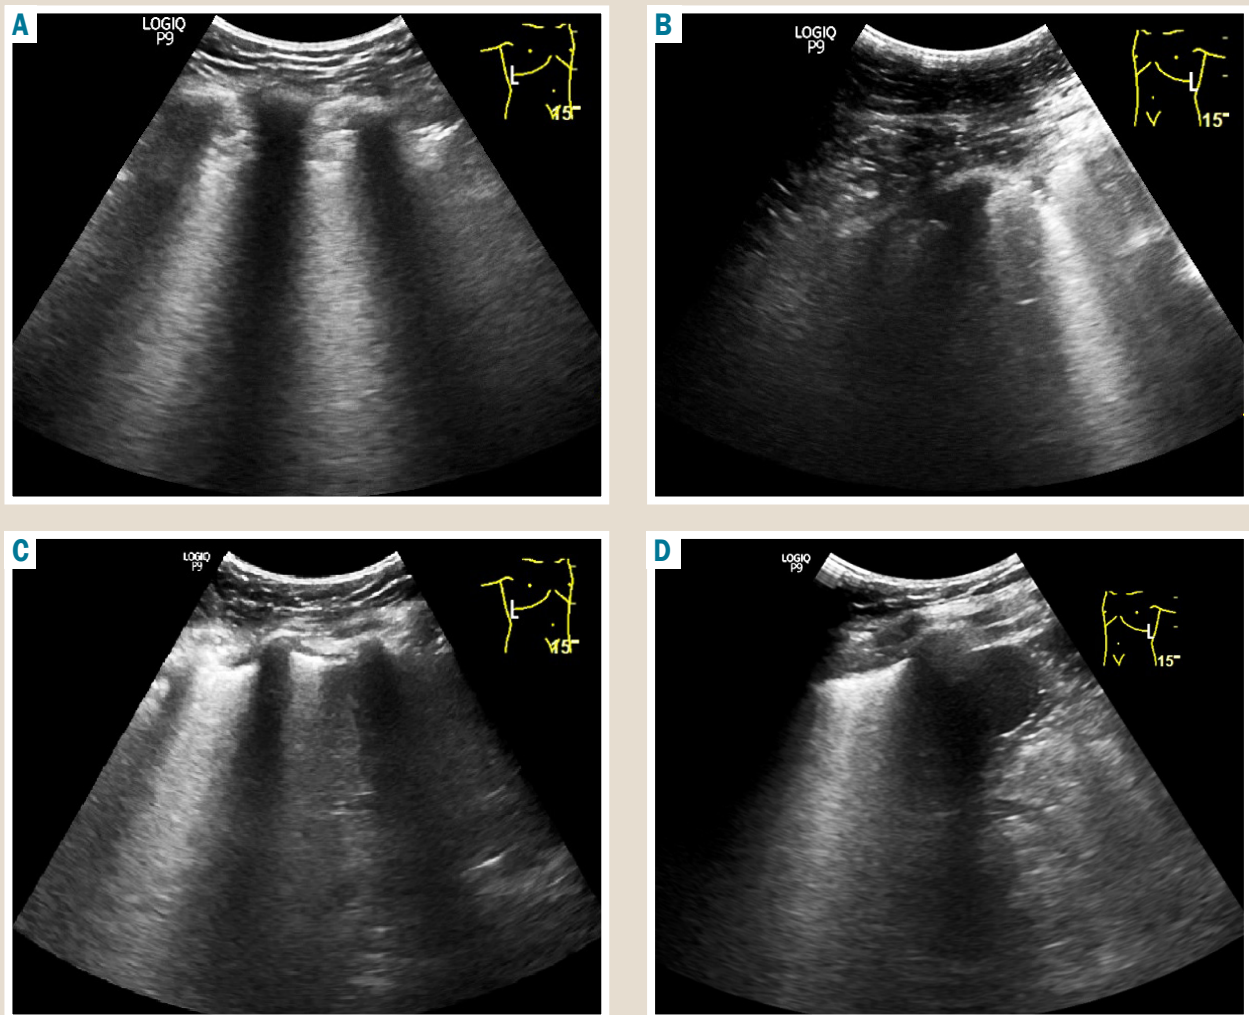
Lung ultrasound examination of the 48-year-old patient S. A, B: upon hospital admission; C, D: in the treatment dynamics.
